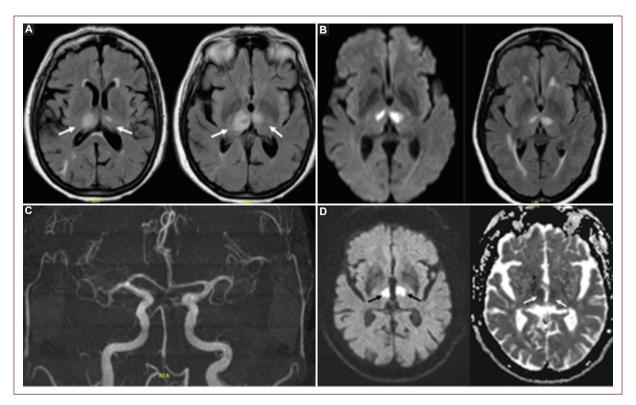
Bilateral thalamic infarction. A: asymmetric bilateral thalamic hyperintensity on FLAIR sequence. B: bilateral thalamic infarction in brain MRI with Time-of-Flight Angiography. C: percheron artery in MR angiography. D: restricted diffusion area at bilateral paramedian thalamic level with representation in ADC Maps sequence.
